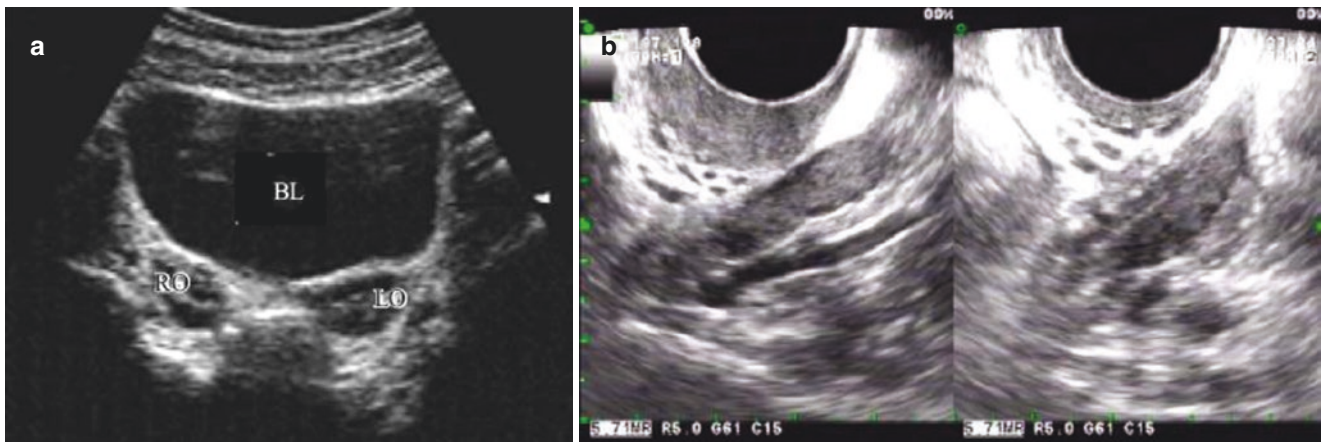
Follicles agensis. (a) During the monitoring through the ovarian period, no follicle is developed. (b) 32-years-old, premature ovarian failure. Sonogram shows no follicle in the atrophied ovary
